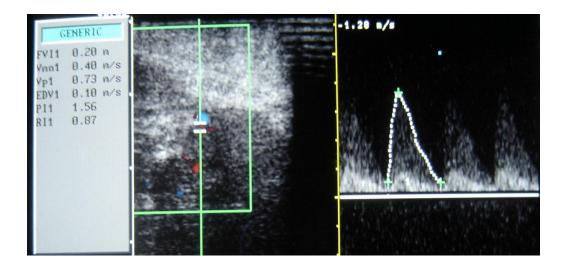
Infiltrating duct carcinoma in a 78 year old patient. The lesion shows central flow. The Doppler spectral waveform has the following indices – PI: 1.56; RI: 0.87; PSV: 71 cm/s; EDV: 9cm/s. This malignant mass has high PI and RI.
